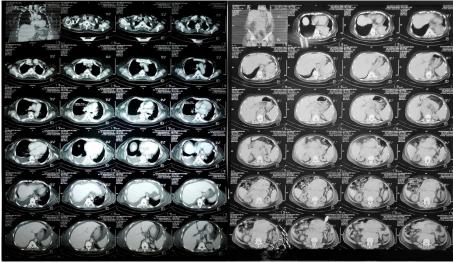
Chest and abdominal CT Scan
